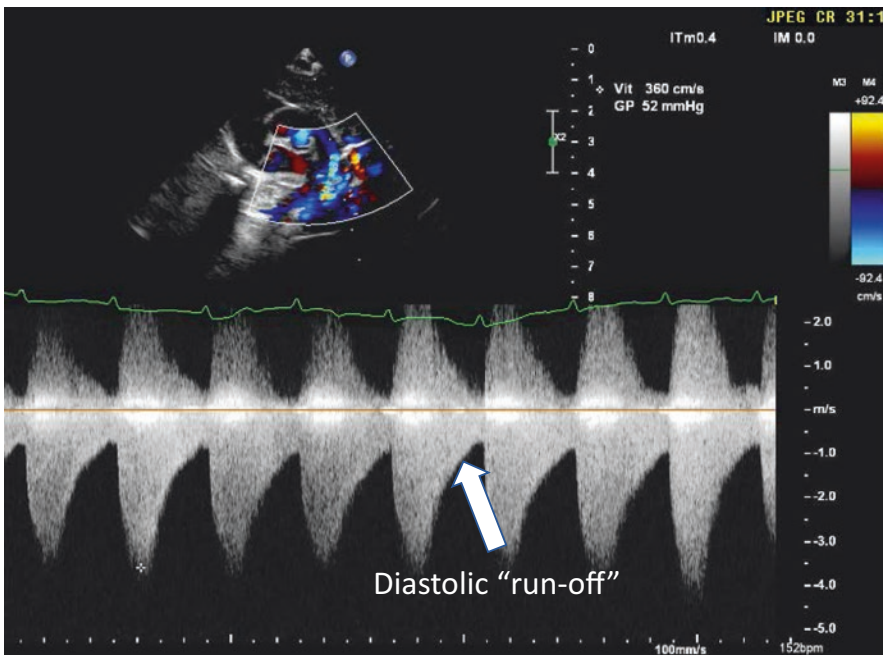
Suprasternal Doppler: high-velocity flow with diastolic “run-off”
